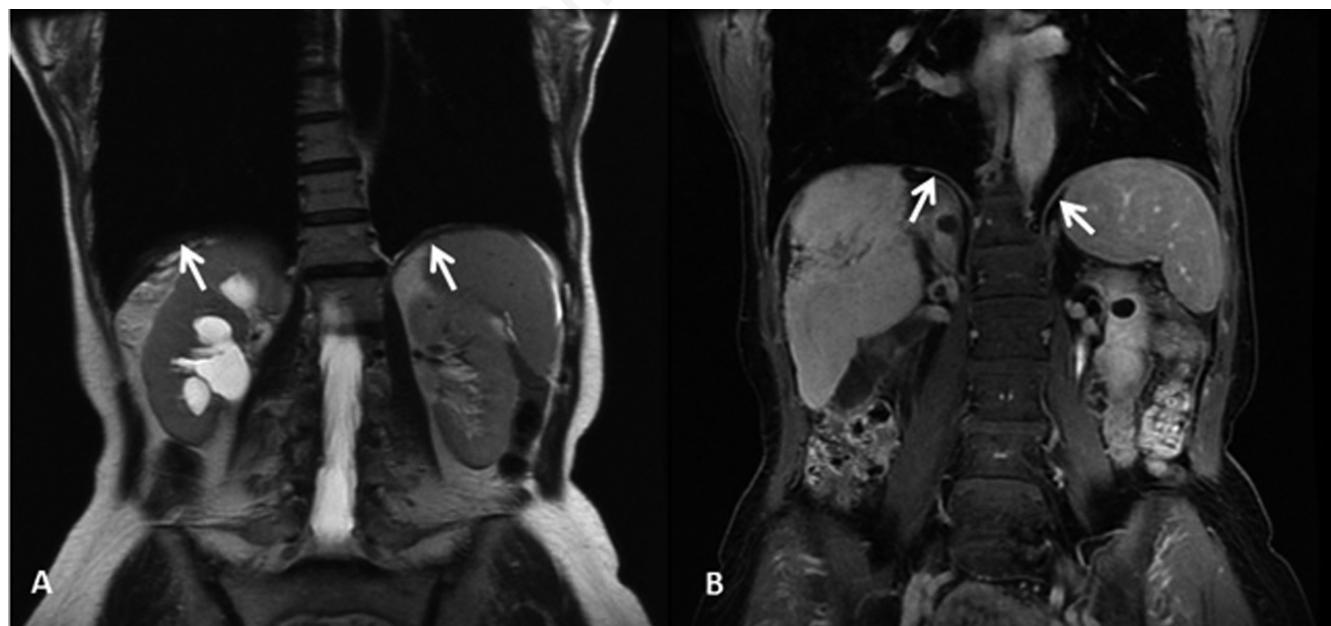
Magnetic resonance imaging (MRI). Different MRI sequences for evaluating the diaphragm from a morphological point of view, better view of the structure in the coronal plane. The so-called “T2 weighted” sequences (A) allow visualization of the diaphragm as a hypointense streak (dark) interposed between two layers of adipose tissue (fat of the sub-pleural space and the sub-diaphragmatic) that are visible as hyperintense (clear). The sequences “T1-weighted after administration of the contrast” (B) use the opposite principle, i.e. they show a diaphragm as a linear structure hyperintense (or clear, as it is soaked by injected contrast) between two layers of adipose tissue hypointense (black, free of impregnation).
